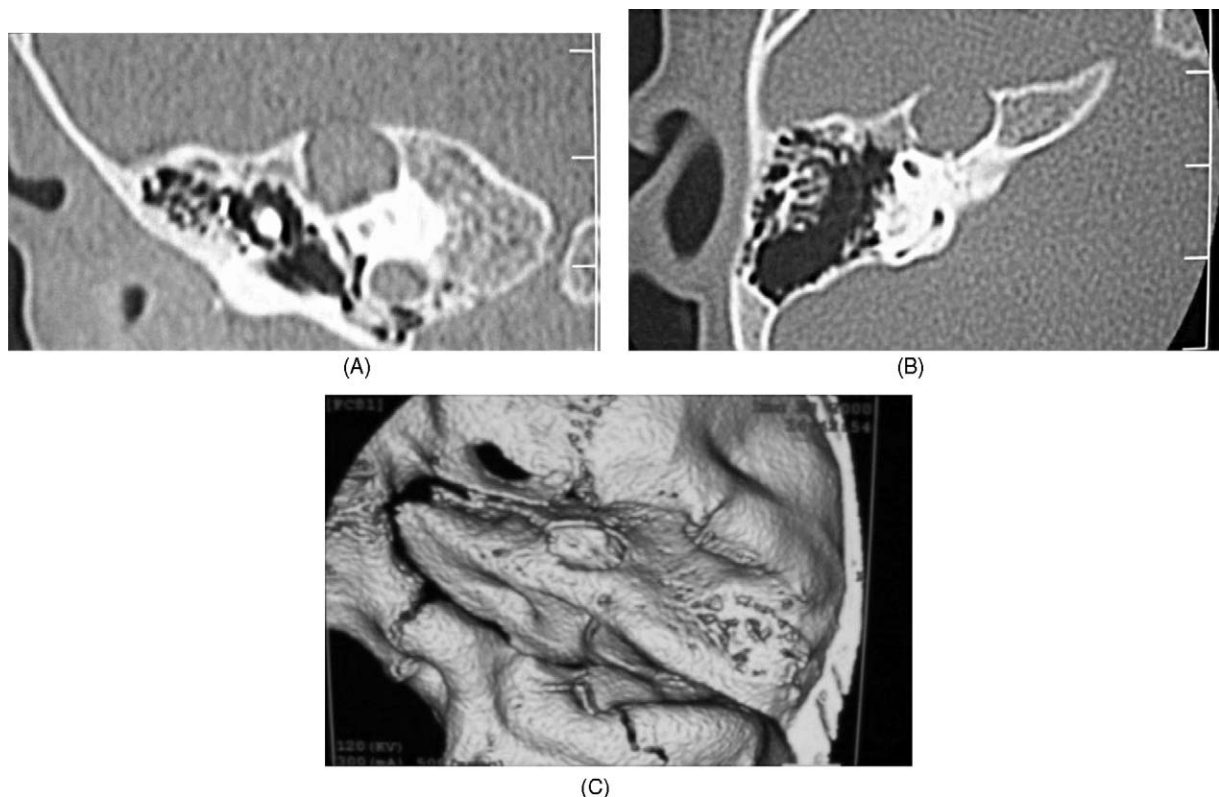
CTscan of the temporal bone. An expansive lesion was identified above the petrous bone on coronal section (A) and forward of the petrous bone on axial section (B). A round destruction image was seen above the acoustic meatus in the middle fossa of the petrous bone, on the superolateral aspect of the bone on three-dimensional CT (C).
